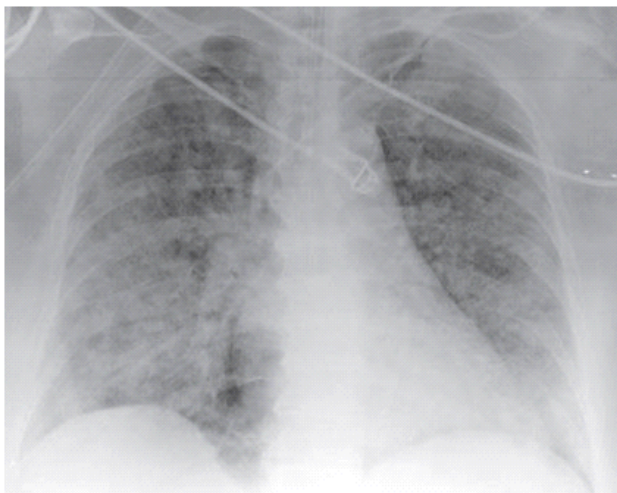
X-ray in the Exudative phase of ARDS
